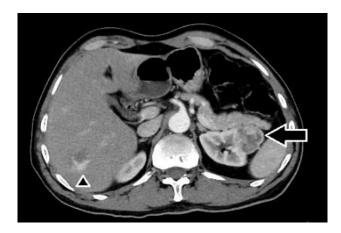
Contrast enhanced CT scan axial slice of an exophytic heterogeneous solitary left renal midpole lesion.
